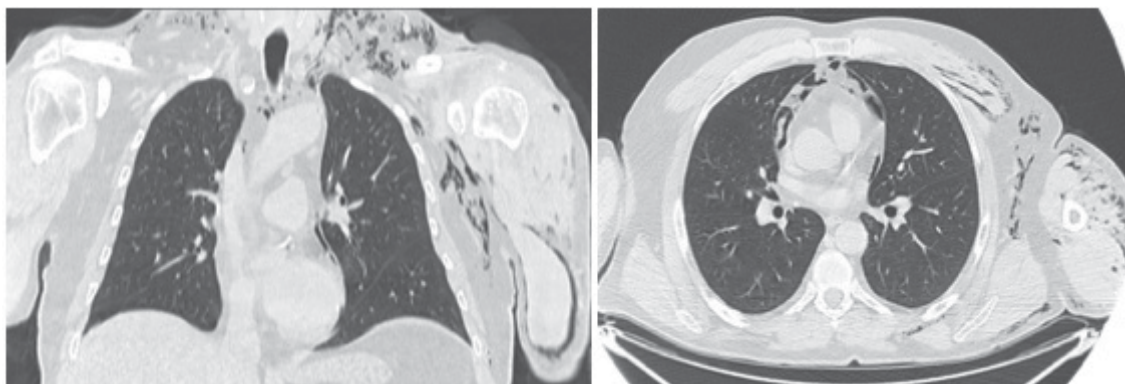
CT scans of the chest.
